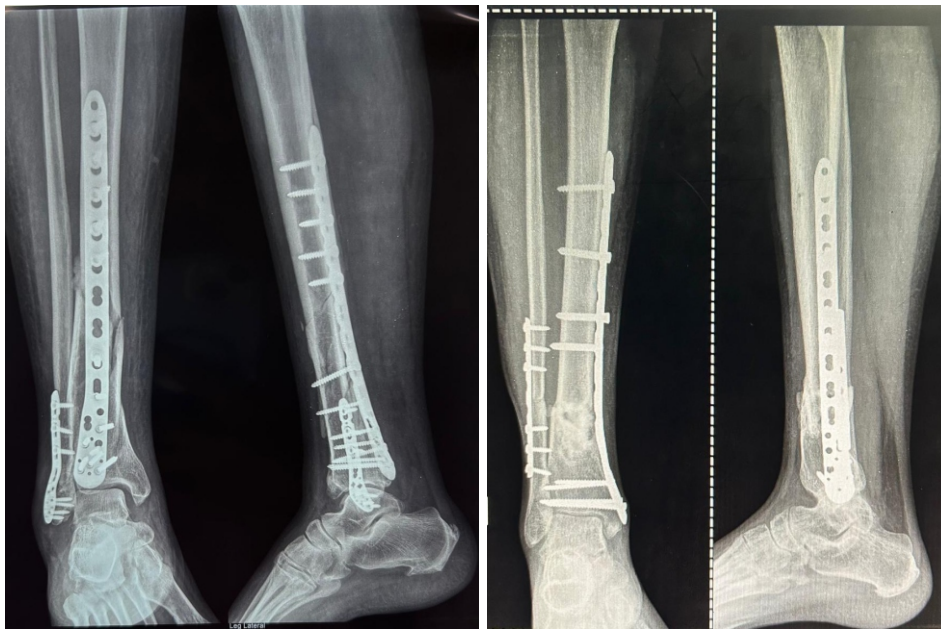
Representative post-operative radiographs showing posterior plating (left) and medial plating (right) with maintained alignment at 6 months.
